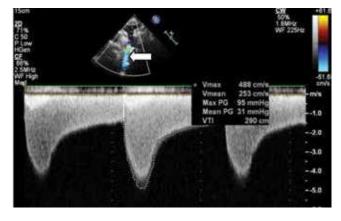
Patient R., 20 years old: suprasternal position along the long axis. Continuous-wave Doppler; the arrow shows stenotic flow at the site of stenosis
